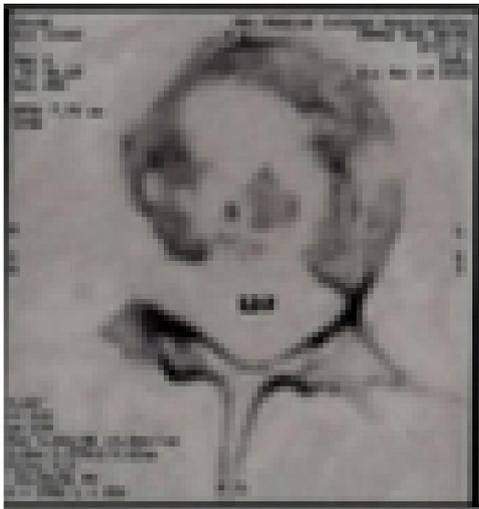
CT DL-Spine showing fragmentation of vertebral bodies (pott's spine)
